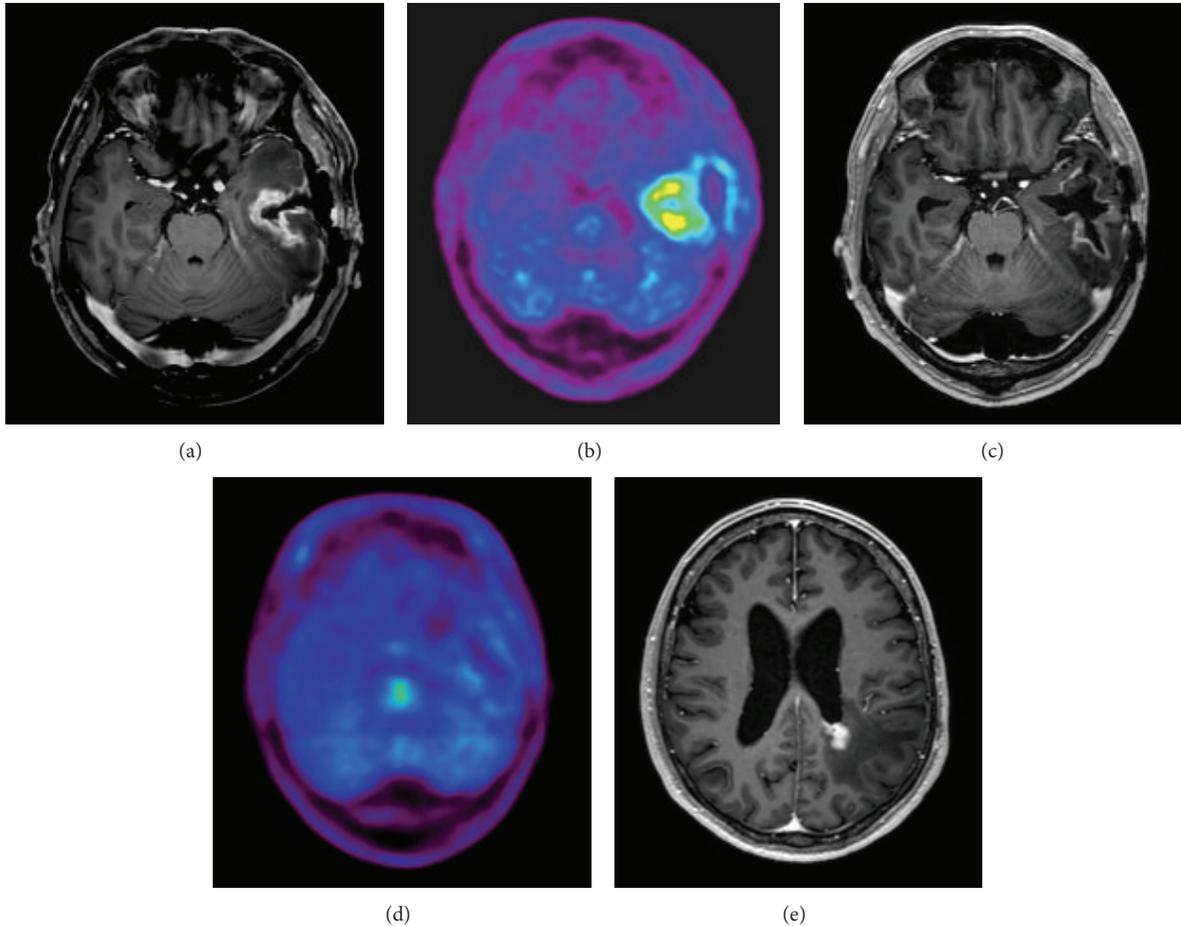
Representative cases of cerebrospinal fluid dissemination: 55-year-old man with GBM. Before Hypo-IMRT, an enhanced tumor was demonstrated in the left temporal lobe on T1-weighted magnetic resonance imaging (MRI) (a). ^{11}C -Methionine positron emission tomography (MET-PET) demonstrated a MET high-uptake region in the left temporal lobe (b). 20 months after Hypo-IMRT, the enhanced tumor was decreased in size (c), and the MET high-uptake region could not be detected distinctly (d), although disseminated lesion was observed around the left lateral ventricle (e).
